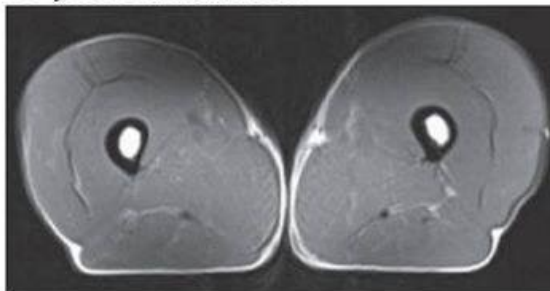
Magnetic resonance imaging scans in quadriceps of a 40-year-old triathlete compared with the quadriceps of a 70-year-old triathlete and a 74-year-old sedentary man. Note the significant visual difference between the subcutaneous adipose tissue and intramuscular adipose tissue of the sedentary man vs master athletes (Wroblewski et al., 2011)
